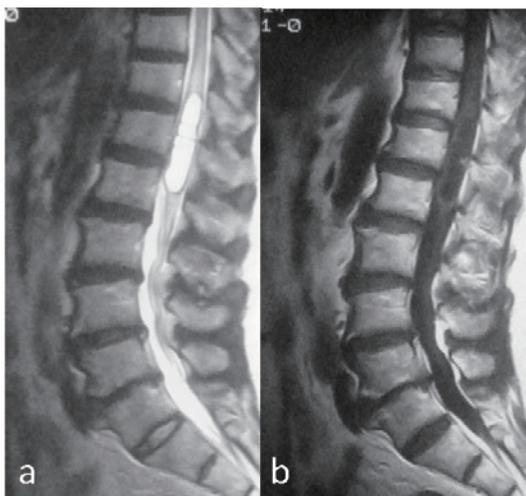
(a) T2 MRI and (b) Gd-enhanced MRI before the initial surgery (nine years ago), showing the presence of an intramedullary tumor.
